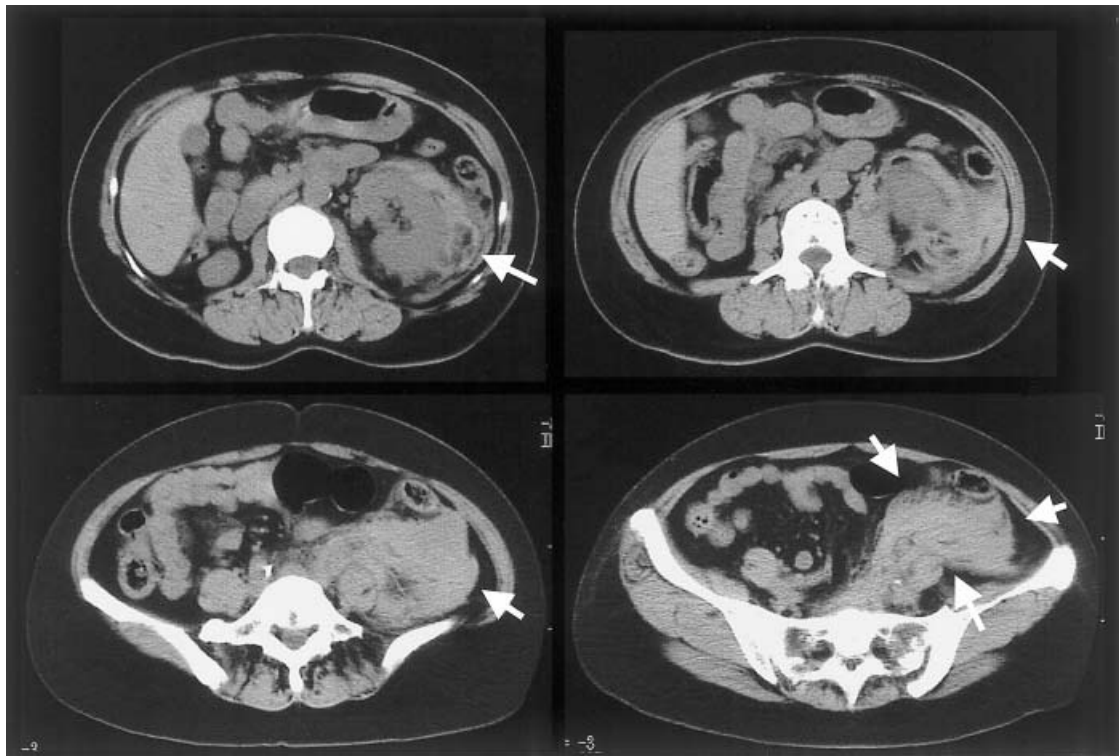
Plain abdominal CT showed a left retroperitoneal hematoma (12×5×4 cm) from around the kidney to pelvic region
